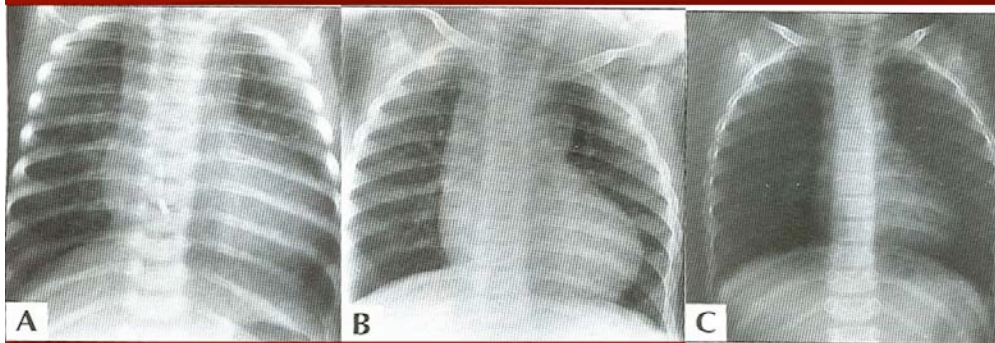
Chest roentgenograms (Posteroanterior views) of babies with tricuspid atresia showing enlarged cardiac size and increased pulmonary vascular markings (A); during follow-up, the size of the heart diminished and the pulmonary vascular markings decreased (B & C). Echocardiographic and angiographic studies demonstrated progressive decrease in the size of the ventricular septal defect.
